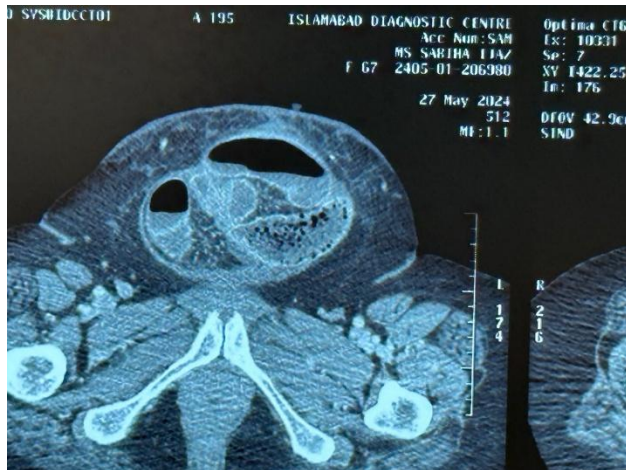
CT abdomen showing interparietal herniation of small bowel loops.
